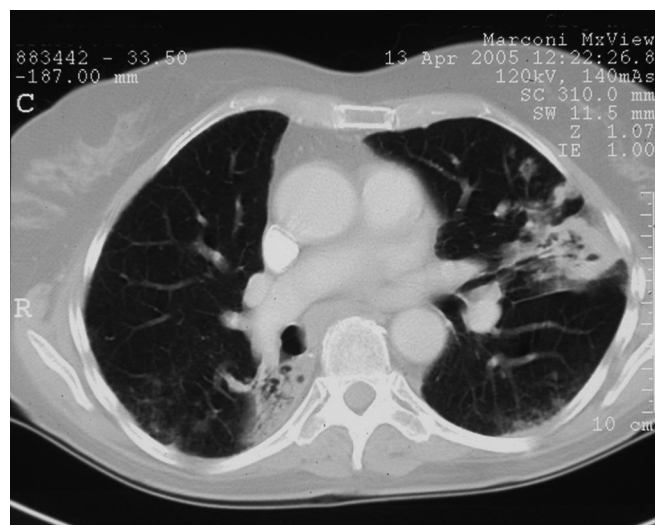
Chest computed tomographic scan before treatment.
